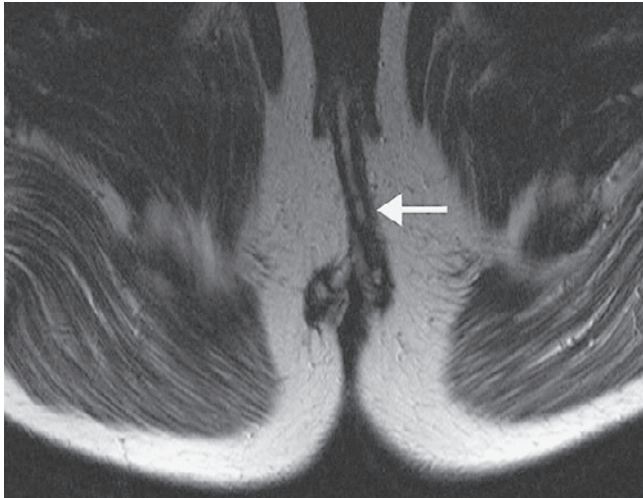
Example of an axial T2-weighted magnetic resonance image of a low transsphincteric anal fistula extending into the scrotum. Two low transsphincteric anal fistulas with anterior internal openings at 10 and 2 o'clock positions are visible on this image. The anal fistula at 2 o'clock position extends into the left scrotum (arrow).
